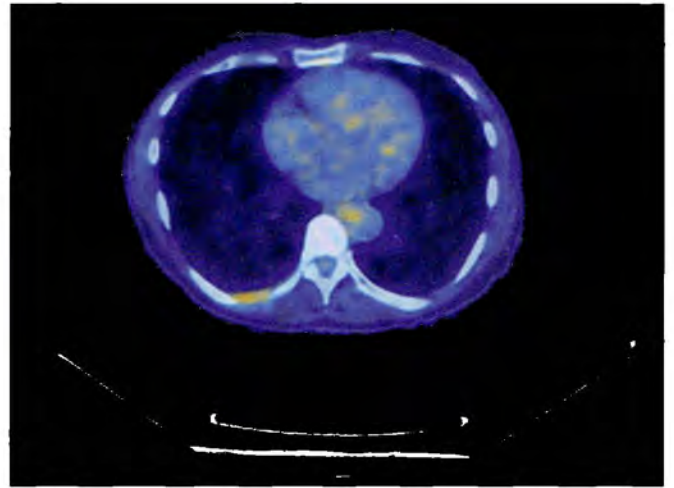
There is a right pleural effusion posterior to the lung with a SUVmax of 3.5.
